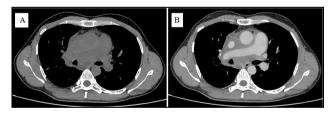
and 2B: Plain and contrast enhanced axial soft tissue CT scan shows a large ill-defined hypodense homogenously mildly enhancing lesion is seen in the anterior and middle mediastinum (prevascular and visceral mediastinum - According to ITMIG classification) encasing the ascending aorta, arch of aorta, its branches, RPA, bilateral brachiocephalic veins, azygous vein and entire length of SVC without significant luminal narrowing and normal contrast opacification.
